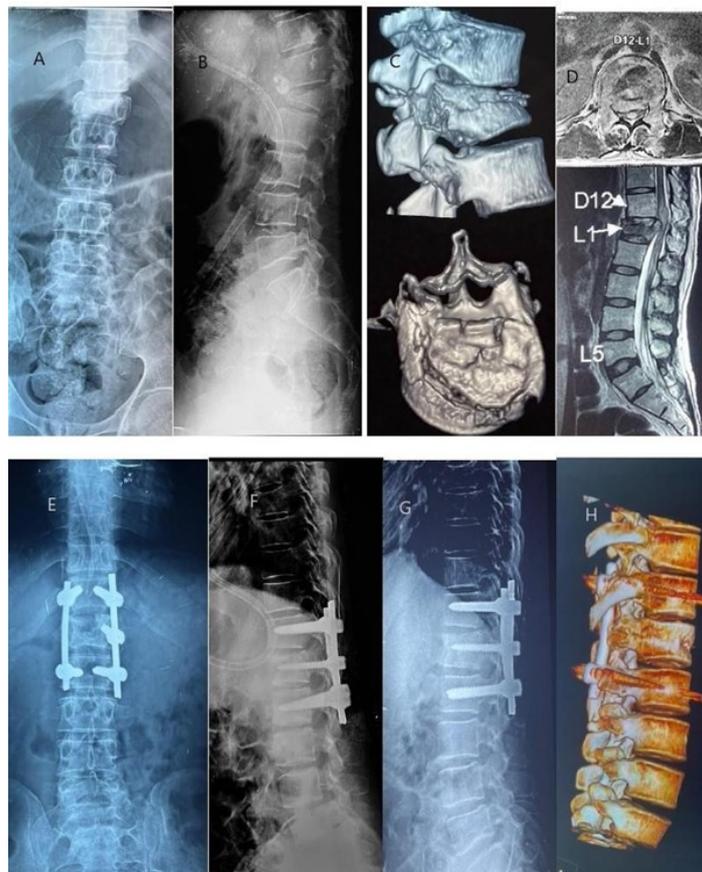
31 year old male with L1 burst fracture. (A-D) Pre-operative images show burst fracture in lateral radiographs, CT scan and retropulsion of fragments in MR images. (E, F) Immediate post-operative radiographs. Pre-operative global kyphosis angle of 34.1° , local kyphosis angle of 48.2° improved to 2.8° and 4.4° respectively in the immediate follow-up. (G, H) Final follow-up radiographs showing gain of vertebral height by 80% compared to pre-operative radiographs
